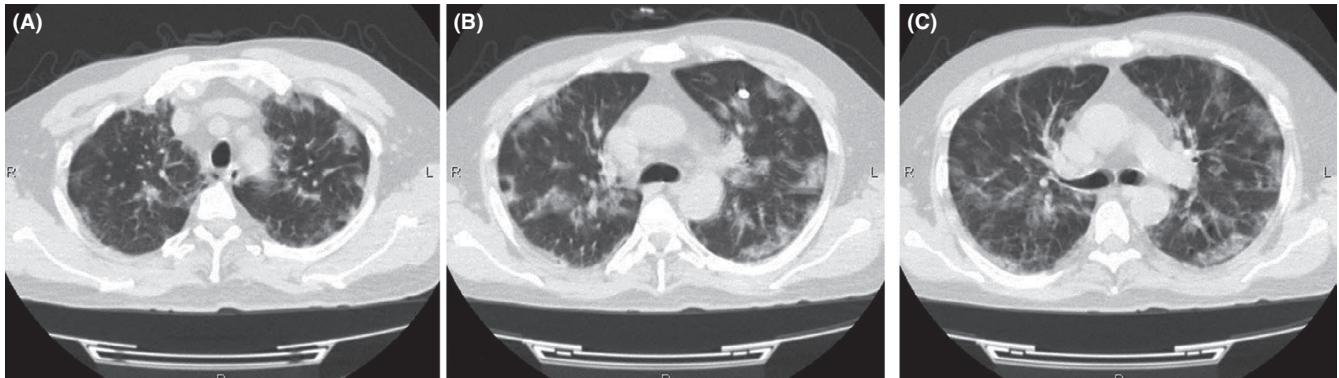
The CT scans show multiple bilateral subpleural GGO fused into larger areas
